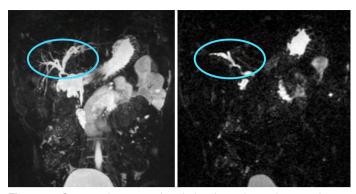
Computed tomography cholangiography and magnetic resonance imaging angiography at post-operative 8th days were normal demonstrated free flow in the hepatic artery, and mild dilatation in the biliary three and common bile duct.
